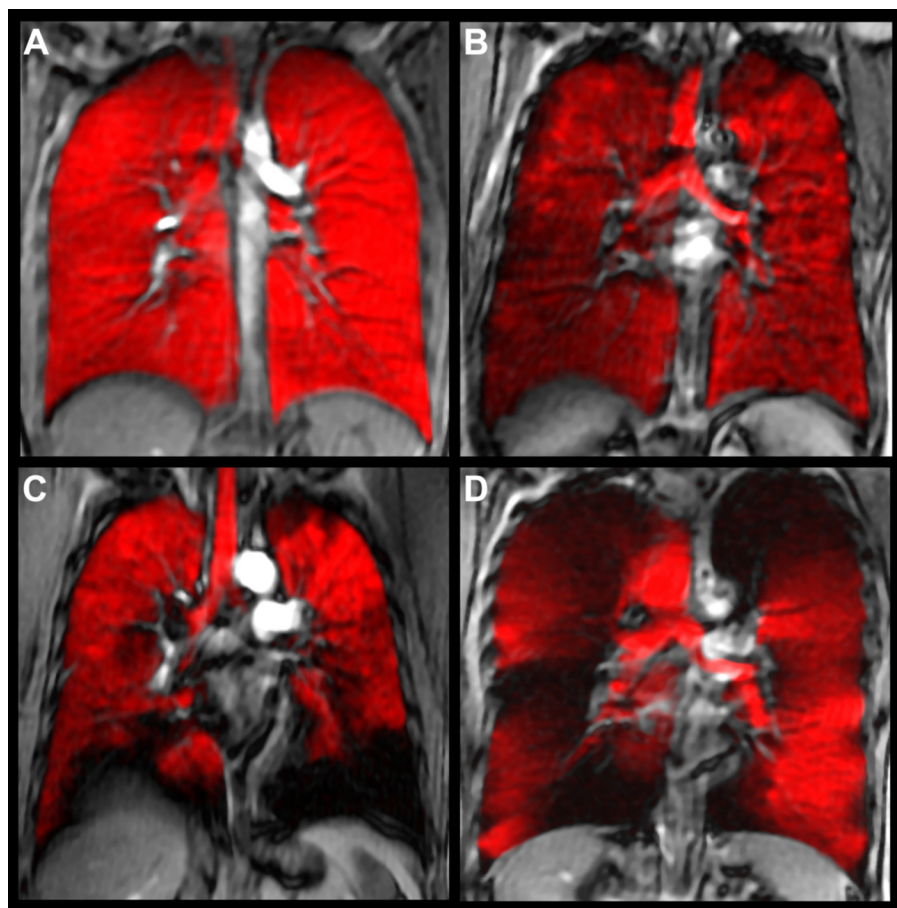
Hyperpolarized ^3He -MRI of gas distribution (in red) coregistered to ^1H -MRI of thoracic cavity (gray scale) of a healthy young never-smoker (A), older never-smoker (B), asthma (C), and COPD (D). MRI was obtained in the coronal plane during inspiration breath hold, after inhalation of a 1 liter gas mixture of hyperpolarized ^3He and ultra-high purity N_2 gas from functional residual capacity. ^1H -MRI preceded ^3He -MRI by ~ 5 min and the ^1H - and ^3He -MRI slices were coregistered using rigid registration methods using the carina for fiducial landmarks. Coregistered ^1H (gray scale)- and ^3He -MRI gas distribution images show gas in red, and focal ventilation defects are clearly shown where the ^1H thoracic cavity is exposed (in black) in the absence of gas. Note the absence of gas distribution abnormalities in A for the healthy young never-smokers, but there are qualitative differences for the elderly never-smoker and much more obvious abnormalities in asthma (C) and COPD (D). Some qualitative differences can also be observed in the gas distribution obvious in the trachea, although for all subjects, the breath-hold maneuver was the same.
